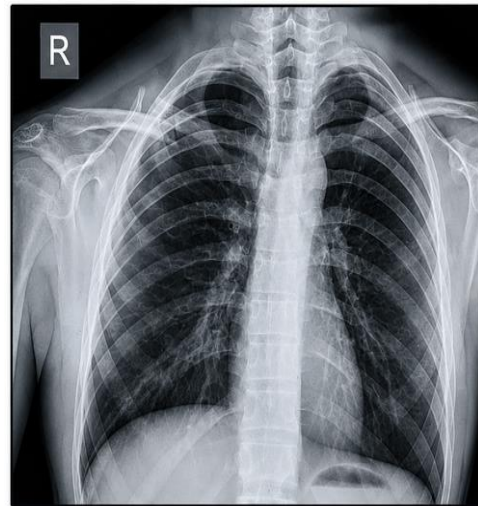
Preoperative anteroposterior radiographs showing a displaced midshaft fracture of the right clavicle with overriding of the fracture fragments. No obvious associated rib fracture or pneumothorax is seen on the available radiographs.
